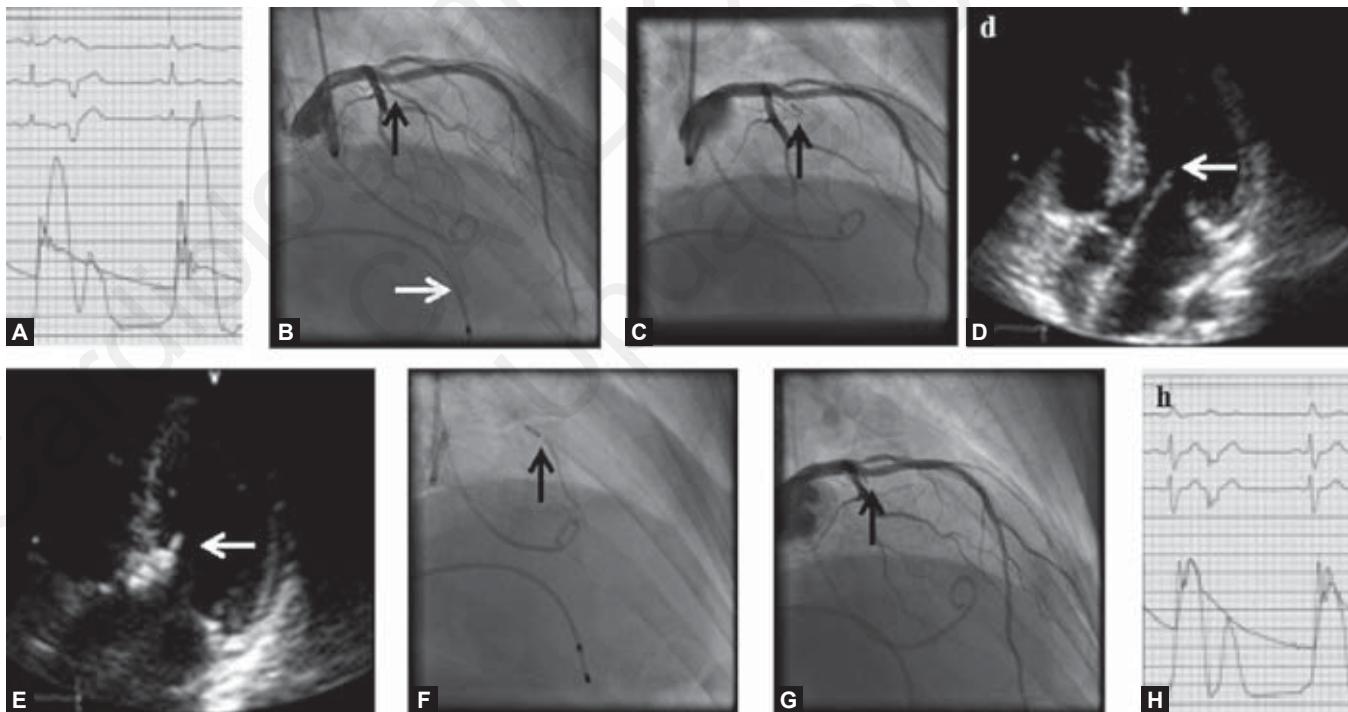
Echo-guided septal ablation (percutaneous transluminal septal myocardial ablation); A, Simultaneous pressure recording of left ventricular outflow tract and aorta at rest and post extrasystole; B, Baseline coronary angiography of the left coronary artery with estimated target branch (black arrow) and temporary pacemaker lead (white arrow); C, Placement of the "over-the-wire" balloon into the target septal branch (black arrow); D, Modified baseline four-chamber view in transthoracic echocardiogram with systolic anterior motion (SAM) septal contact (arrow); E, Echo contrast depot in the basal septum at SAM septal contact (arrow); F, Injection of contrast dye through the central lumen of the "over-the-wire" balloon (arrow); G, Occluded septal branch (branch) after balloon withdraw 10 minutes after last alcohol injection; H, final hemodynamic measurement with gradient at rest and post extrasystole.
